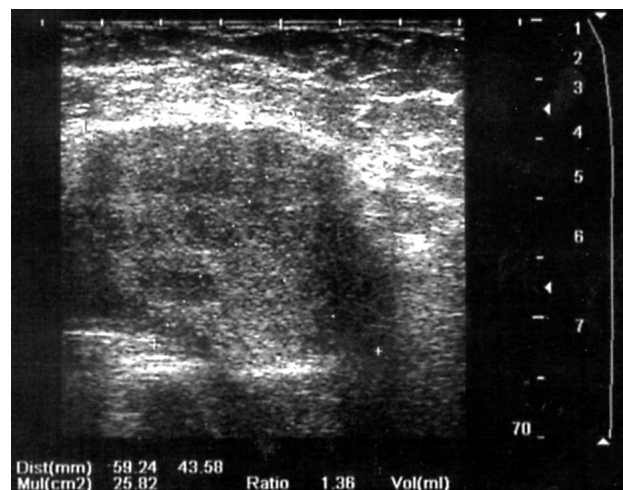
Sonographic appearance of the recurrence in the region of lateral pelvic wall.
